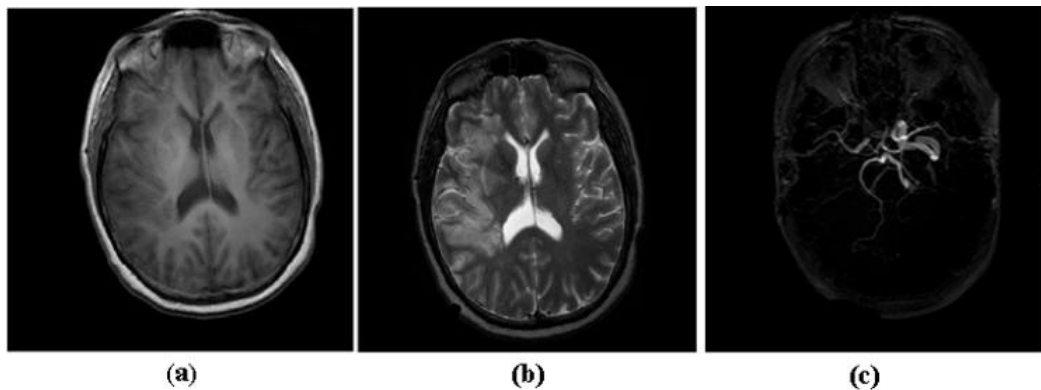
Multiple MR images were acquired to help neurologists diagnose a stroke patient who had middle cerebral artery occlusion in comparison to the right side of the brain. (a) T1-weighted (T1), (b) T2-weighted (T2), (c) 3D MR (Zhu, 2003)
